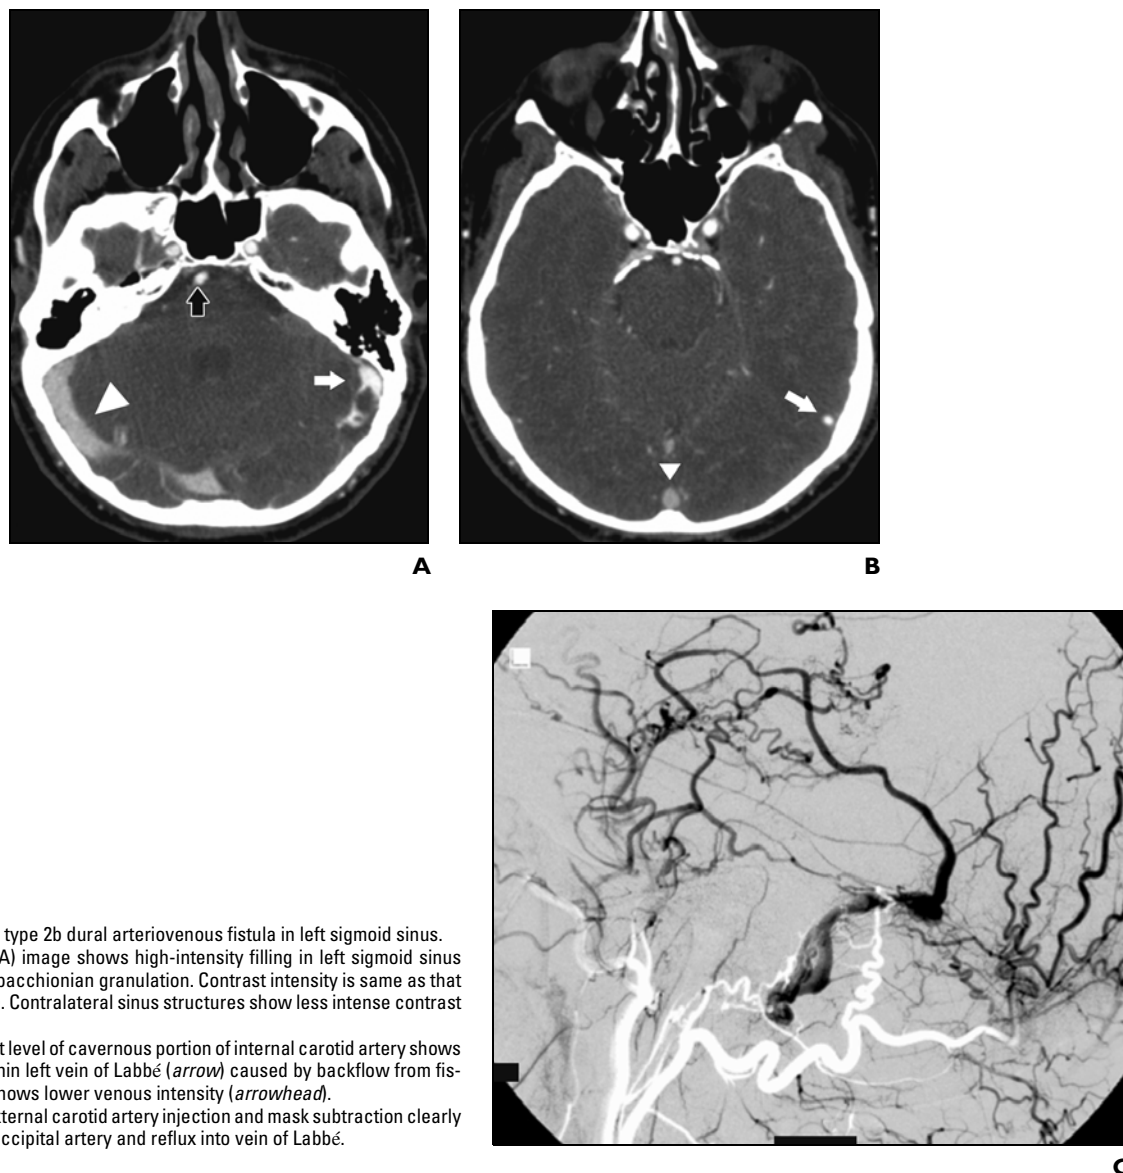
70-year-old man with type 2b dural arteriovenous fistula in left sigmoid sinus. A, Axial CT angiographic (CTA) image shows high-intensity filling in left sigmoid sinus (*white arrow*); note adjacent pachionian granulation. Contrast intensity is same as that of basilar artery (*black arrow*). Contralateral sinus structures show less intense contrast intensity (*arrowhead*). B, Axial CTA image obtained at level of cavernous portion of internal carotid artery shows arterial contrast intensity within left vein of Labbé (*arrow*) caused by backflow from fistula. Superior sagittal sinus shows lower venous intensity (*arrowhead*). C, Cerebral angiogram with external carotid artery injection and mask subtraction clearly shows arterial feeders from occipital artery and reflux into vein of Labbé.
